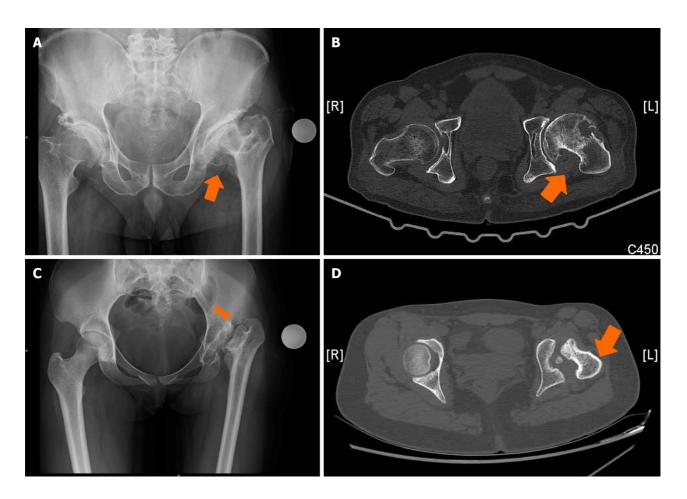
Anatomical abnormalities in the proximal femur include anteversion changes. A and B: X-ray of both hips anteroposterior (AP) showing dysplastic hip left with computed tomography (CT) assessment showing increased anteversion and deformed head and acetabulum; C and D: X-ray of both hips AP showing postseptic sequelae in left hip at total hip arthroplasty with computed tomography (CT) images showing large medial osteophyte, head malformation and increased femoral anteversion. Arrows indicating the changes in the X-ray and CT images. Preoperative evaluation helps in identification and adjustment of intraoperative femoral version.
